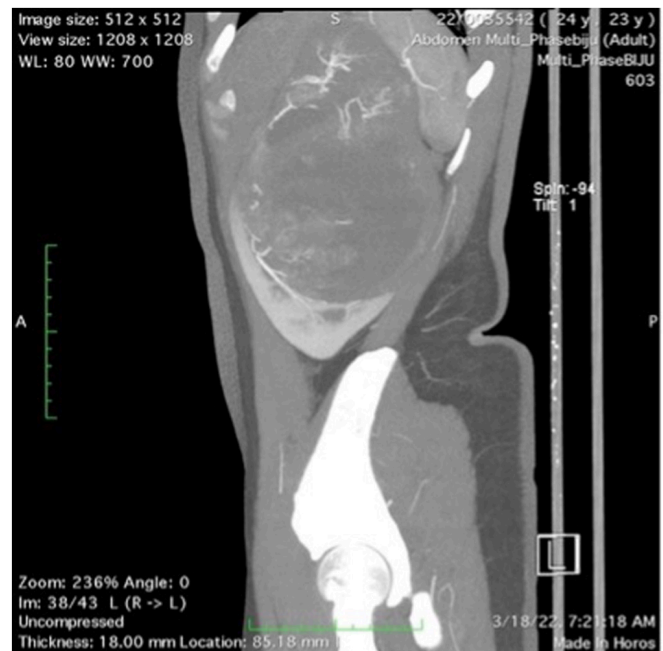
Abdomino-pelvic computed tomography scan showing left Wilms tumor (sagittal view).
